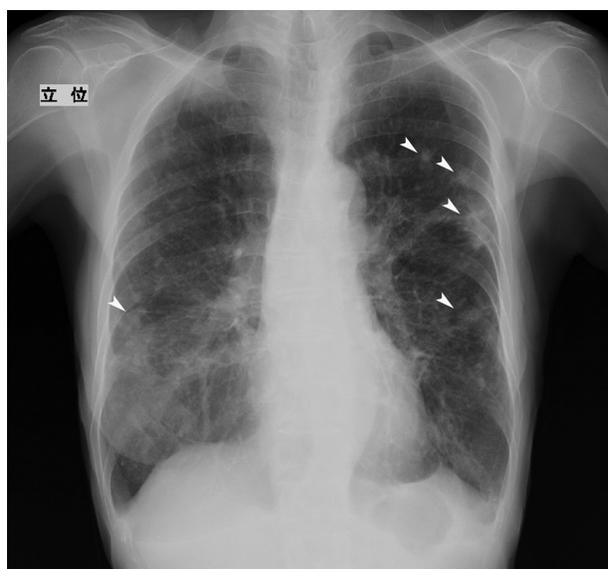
Chest radiograph shows multiple round opacities in both lungs.
